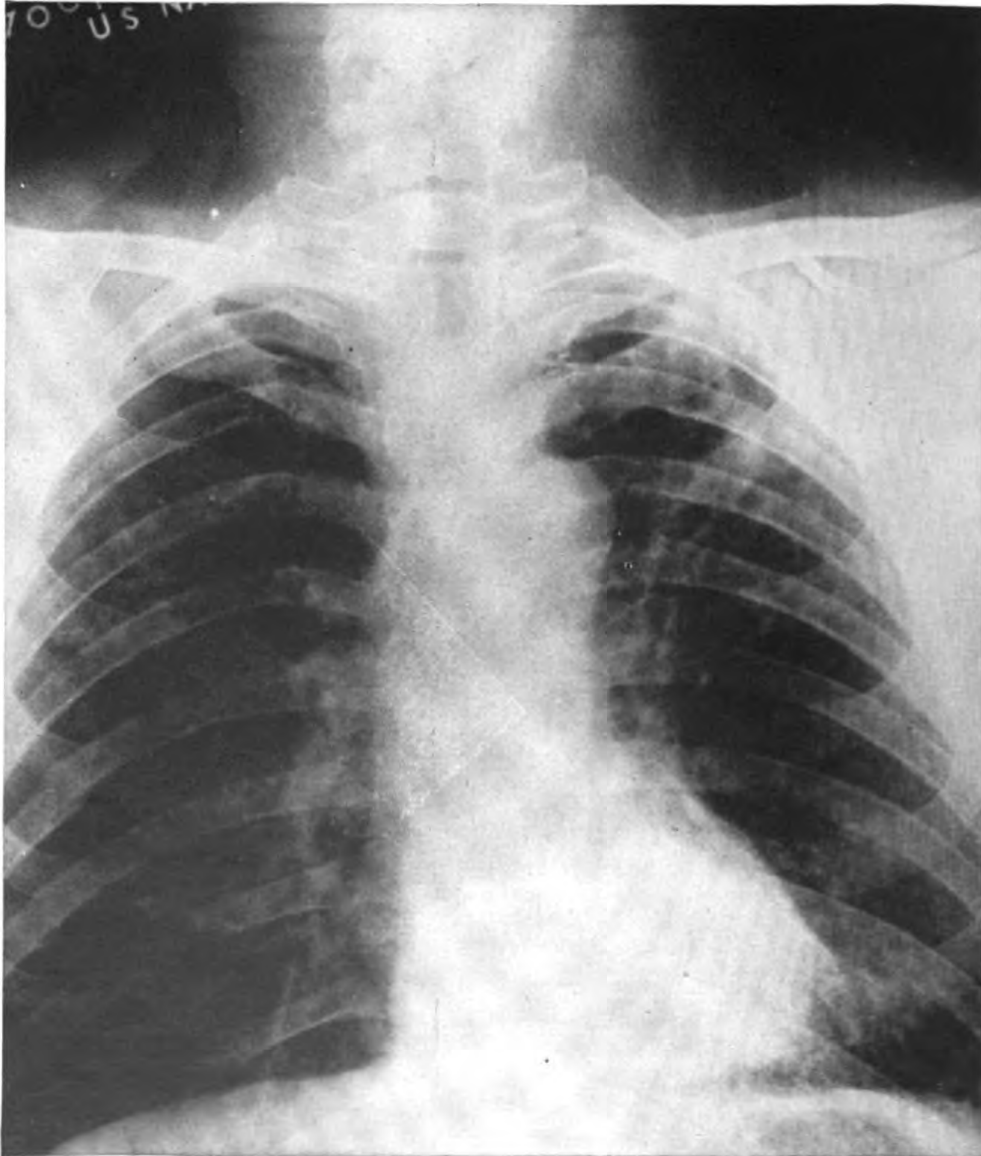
(October 1947) Roentgenogram indicating hazy and indistinct left dome of diaphragm. Areas of confluent density left lower lung field. Left upper lung field shows thickened, hazy, superiorly radiating bands of density, infraclavicular cavitation, and exudative processes. Early exudative infection of right upper lung field.
